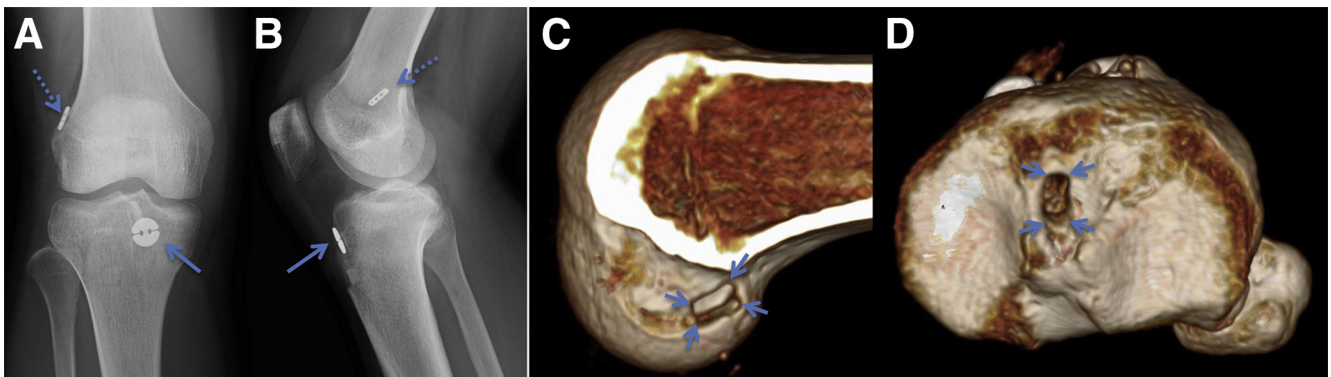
Radiographic postoperative findings of right knee. (A, B) Simple radiographs. The bone–patellar tendon–bone graft is fixed to the femoral bone by a BTB TightRope (dashed arrows) and to the tibial bone by an ABS Suture Button (solid arrows). (C, D) Three-dimensional computed tomography scans taken 3 weeks postoperatively. One should note the rectangular bone socket of the femur and the rectangular bone tunnel of the tibia in the attachment portions of the anterior cruciate ligament (arrows).
